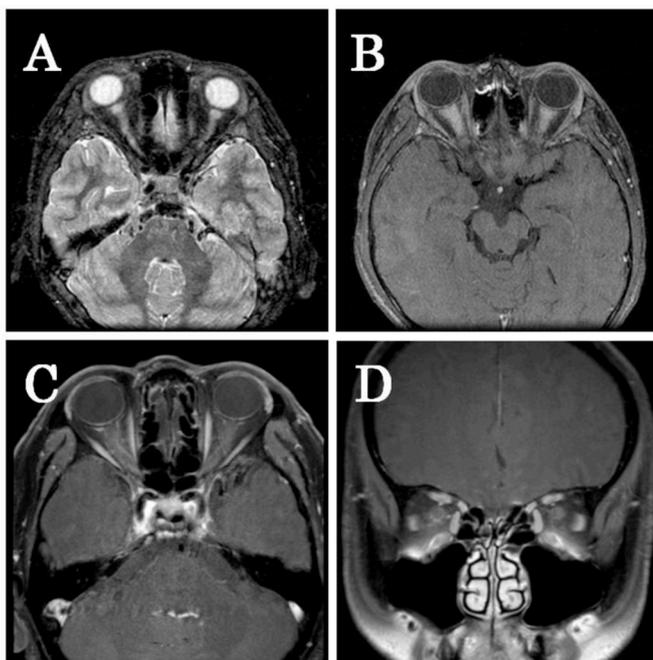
Representative MRI images of acute optic neuritis in MOG-IgG (+) disease. (A, B) Short-tau inversion recovery and fat-suppressed contrasted T1-weighted MRI images in a 17-year-old male with serum MOG-IgG. The optic nerves on both sides are swollen with high-signal in the surrounding intra-orbital fat tissues, which is suggestive of inflammation. (C, D) Axial and coronal views of fat-suppressed contrasted T1-weighted MRI images in a 72-year-old male initially diagnosed with optic perineuritis. Contrast-enhancement can be seen around the right optic nerve.
